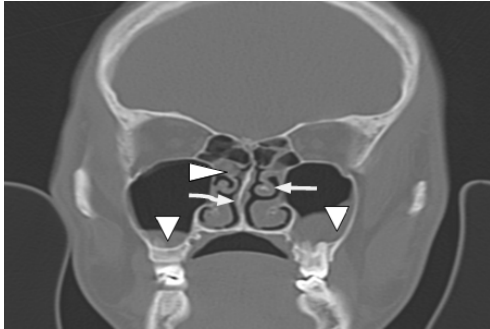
CT scan PNS coronal section showing concha bullosa on the right side (curved arrow) and DNS to the left side (arrow).
